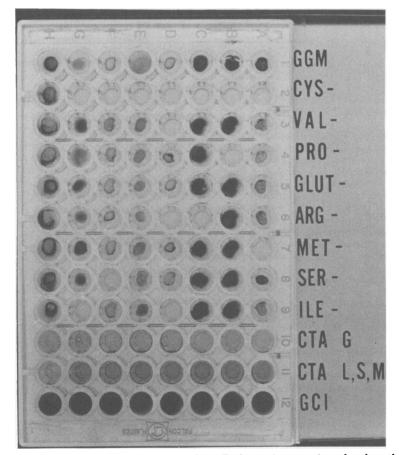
Analysis of auxotypes by miniplate procedure. Eight strains were inoculated on the miniplate as described in the text. Rows A through G are different isolates of N. gonorrhoeae; row H is a strain of Neisseria meningitidis. Rows 1 through 12 are as follows: (1) complete GGM; (2) complete GGM minus cysteine/cystine; (3) complete GGM minus valine; (4) complete GGM minus proline; (5) complete GGM minus glutamic acid; (6) complete GGM minus arginine; (7) complete GGM minus methionine; (8) complete GGM minus serine; (9) complete GGM minus isoleucine; (10) CTA-glucose; (11) CTA-lactose-sucrose-maltose; (12) GCI with oxidase reagent added. Note that all N. gonorrhoeae require cysteine. Auxotypes appear as follows: strain A, Met; strain B, Pro; strain C, Arg; strain D, Val, Arg, Ile; strain E, wild type; strain F, Ser; strain G, Ile; strain H, N. meningitidis.
